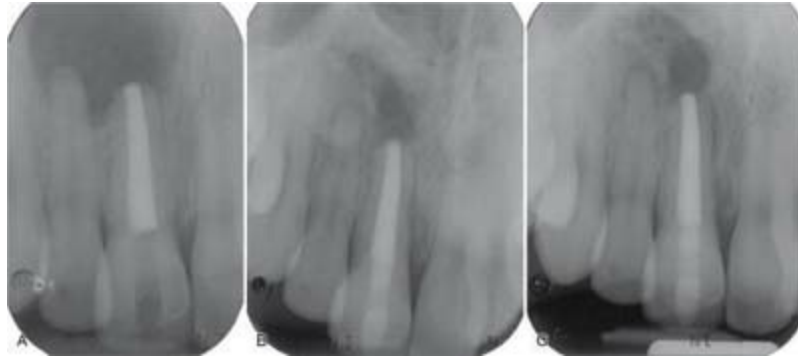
Example of uncertain healing. Periapical radiographs of a maxillary left central incisor taken immediately after periapical surgery (A), at 2 years postoperatively (B), and at 3 years postoperatively (C).
